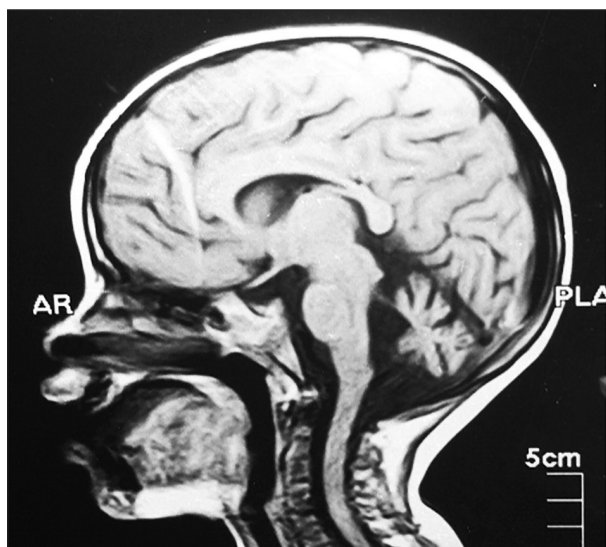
Cranial MRI showing cerebellar atrophy
